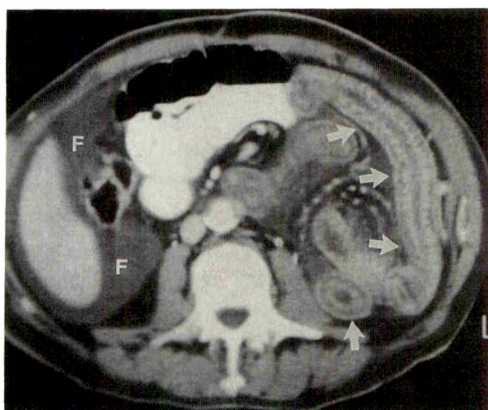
CT scan of ischemic enteritis showing alternate rings of high, low, and high attenuation in a symmetrical, circumferential, and slightly thickened bowel wall (arrows). Distribution is segmental, and there is associated intraperitoneal hemorrhagic fluid (F).
